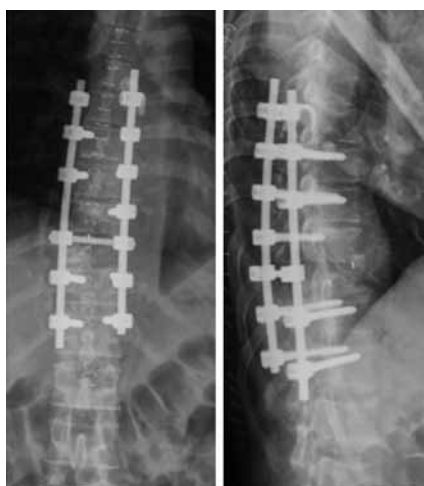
Postoperative radiographs: Anteroposterior and lateral views
